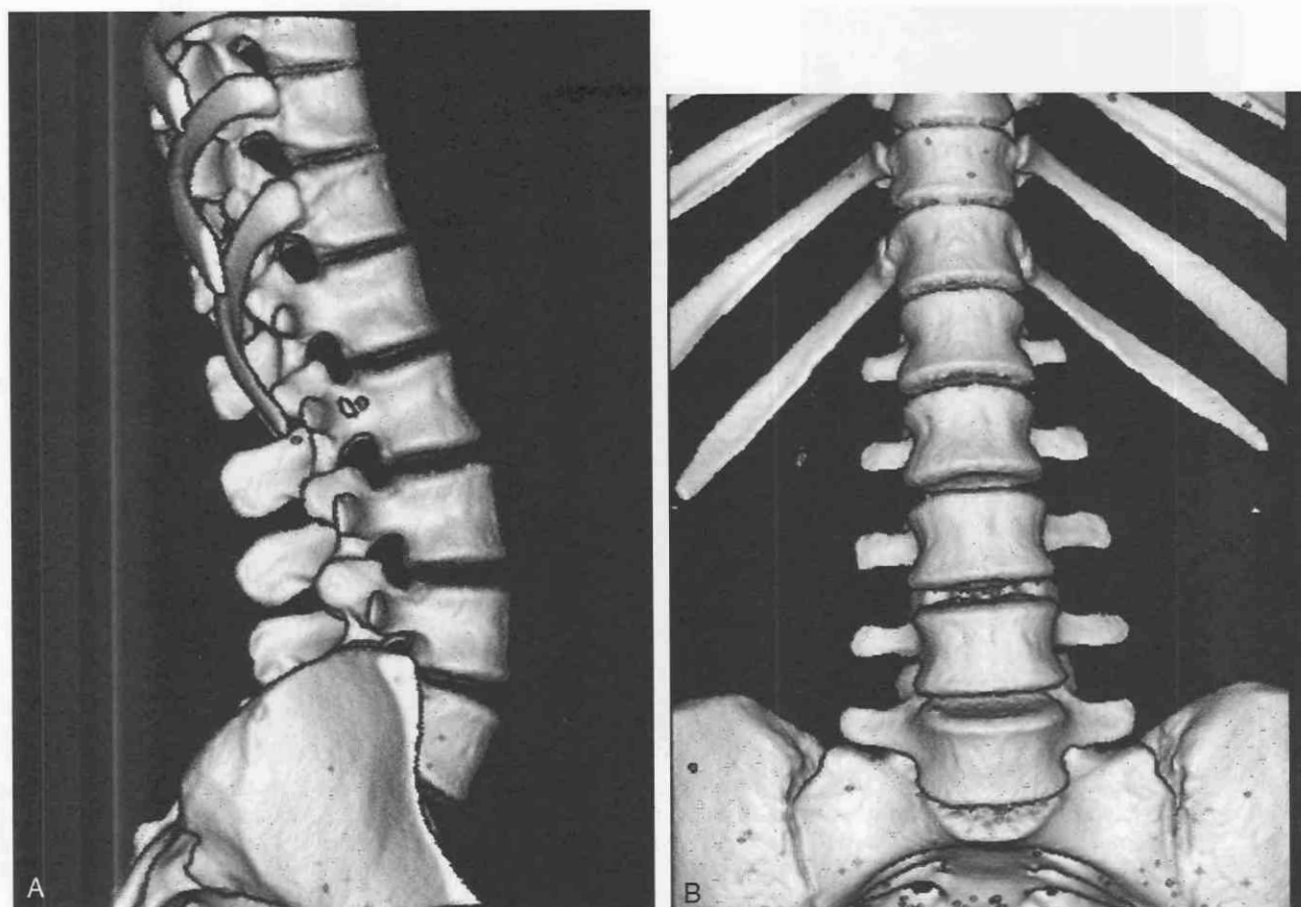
Lateral (A) and frontal (B) 3D images of the lumbar spine reconstructed from 1.5-mm-thick axial data on a helical CT scanner. Images can be rotated in any direction, thus providing a “virtual” surgical field.
